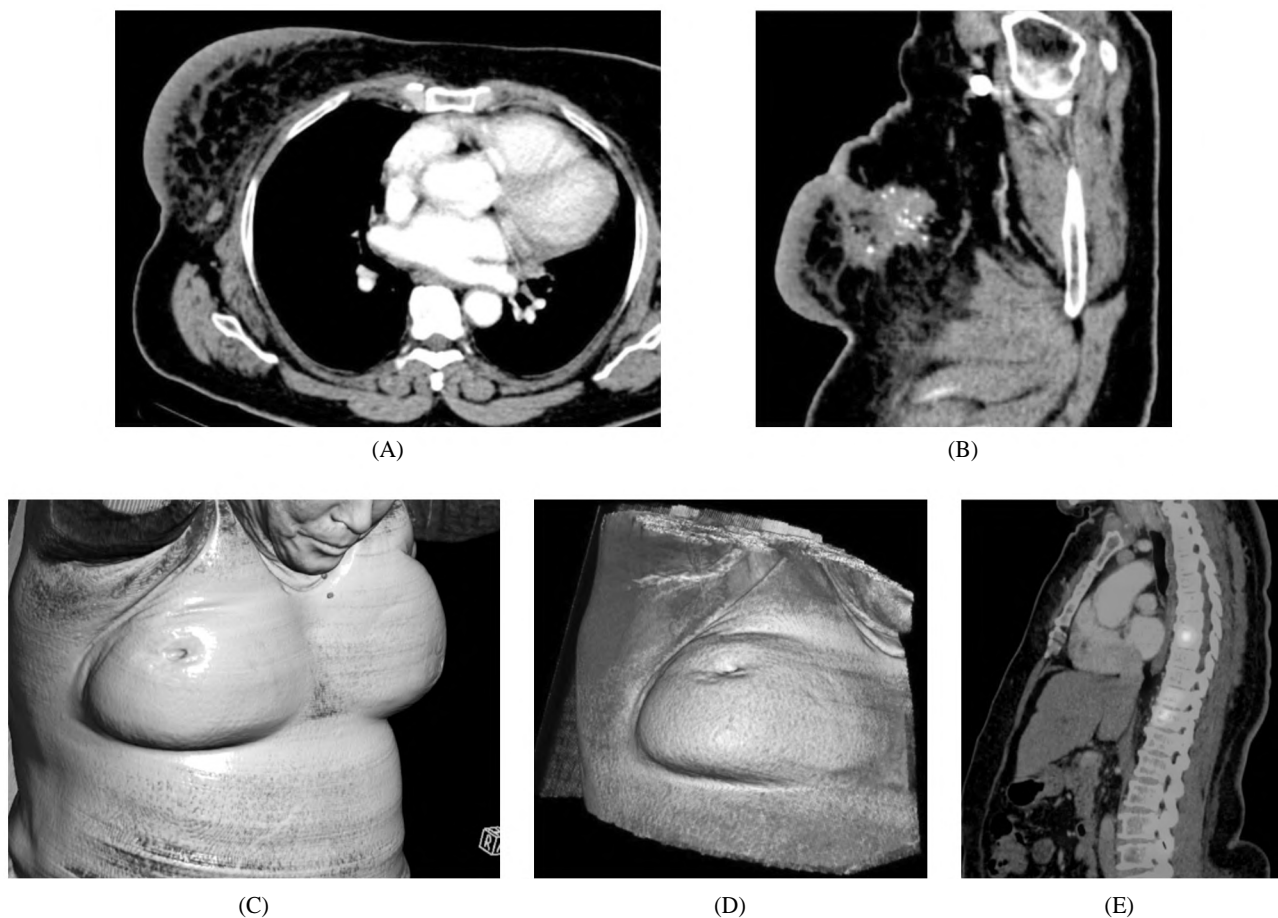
(A,B): Axial and sagittal CECT showed heterogeneous speculated right retro-areolar breast mass with multiple clusters of calcifications. (C,D): Coronal VRT clearly demonstrates the skin retraction and peau d'orange. (E): Sagittal SPECT-CT displaying the active tracer uptake of bony metastatic lesions.
